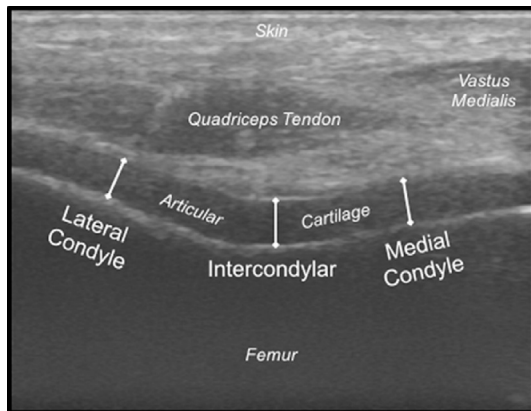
Ultrasound has been utilized as a tool to measure cartilage thickness *in vivo*. In this study, cartilage thickness was measured in three locations within a single image (lateral condyle, intercondylar space, and medial condyle) and was defined as the distance between the cartilage-bone and synovium-cartilage borders. Image from Harkey et al.²³.
